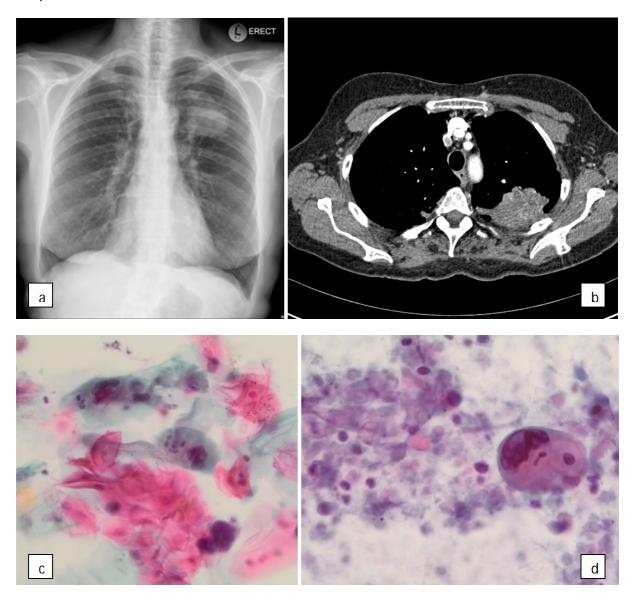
Circumscribed, lobulated mass in left upper lobe abutting the pleura on chest X-ray (a) and CT (b). Sputum – malignant. Large cells with dense cytoplasm and nuclear irregularities (c). These cells were missed with manual screening. TBNA - Squamous cell carcinoma, predominantly keratinising type with necrosis (d).
